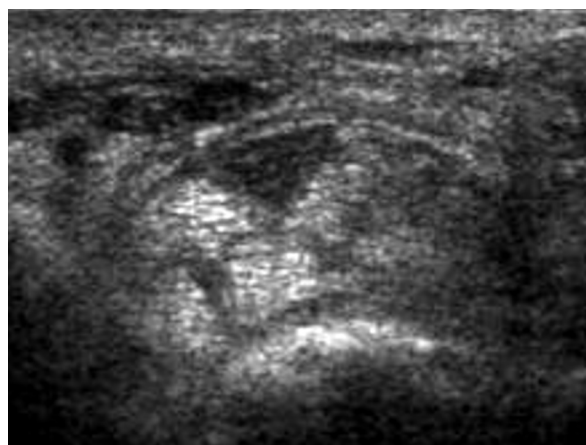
Carpal tunnel syndrome in a 79-year-old woman. Transverse 5-12 MHz sonographic scan shows triangular deformation of the enlarged (16 mm²) median nerve cross-section
